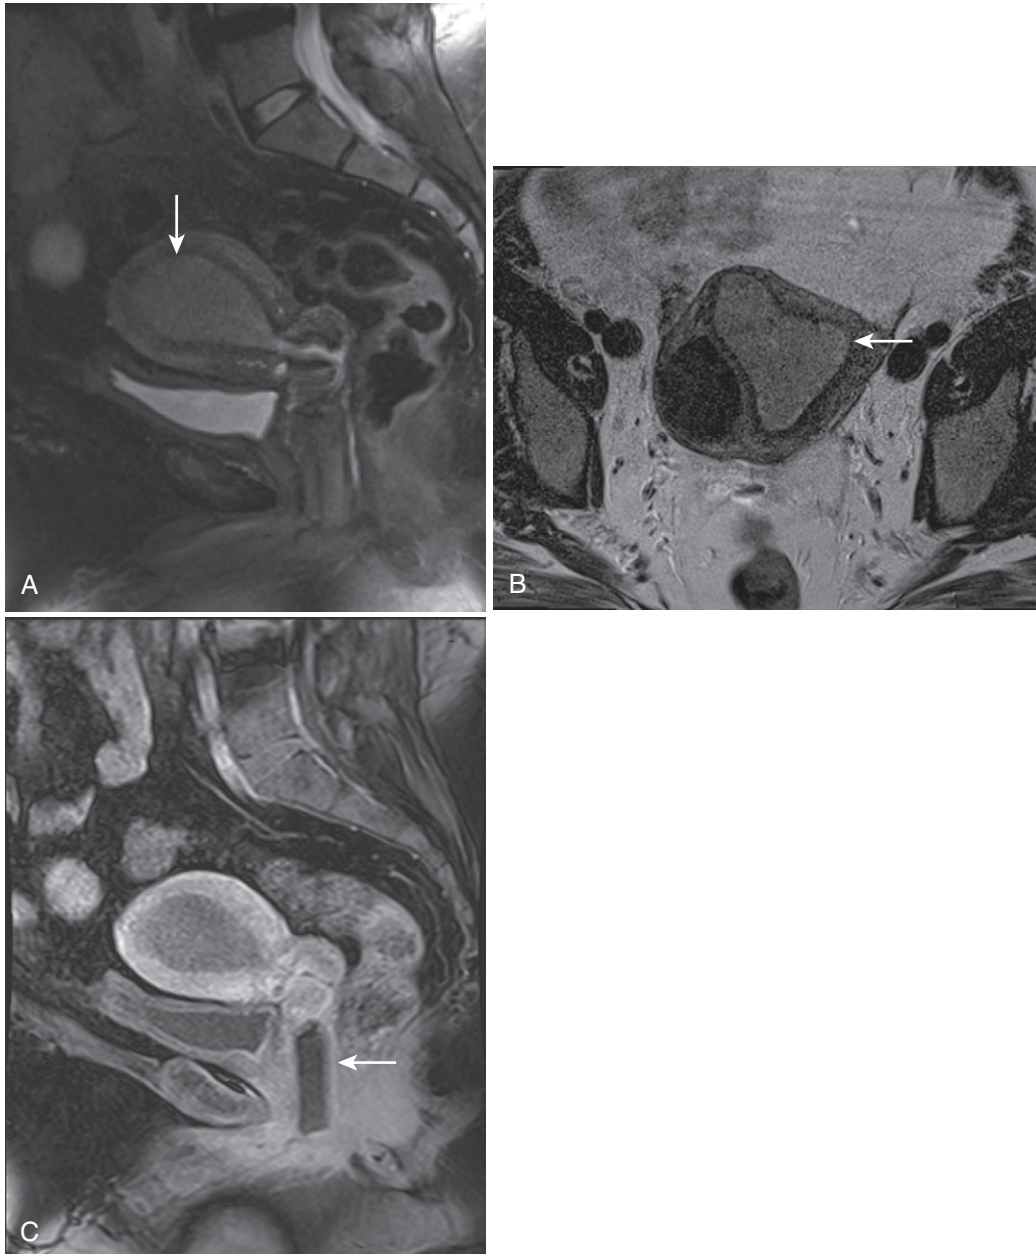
Endometrial carcinoma (sessile type). Sagittal T2-weighted fat-suppressed (A) and axial T2-weighted (B) images depict a mildly hyperintense endometrial mass (*arrow*) within the hypointense junctional zone, indicating lack of deep myometrial invasion. C, Relative hypointensity of the mass after gadolinium administration indicates hypovascularity. Note susceptibility artifact arising from a tampon (*arrow*).
